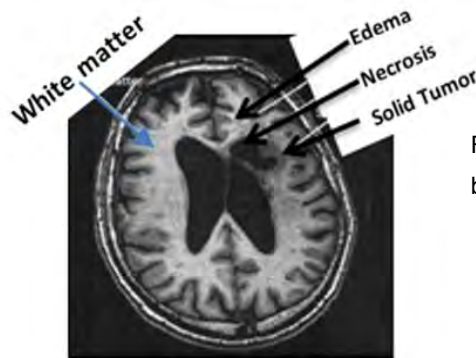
one axial slice of a MR image of the brain showing solid tumor, necrosis and edema [Curtsey of P. Reimer et al. (eds.), Clinical MR Imaging, Springer-Verlag Berlin Heidelberg 2010]
